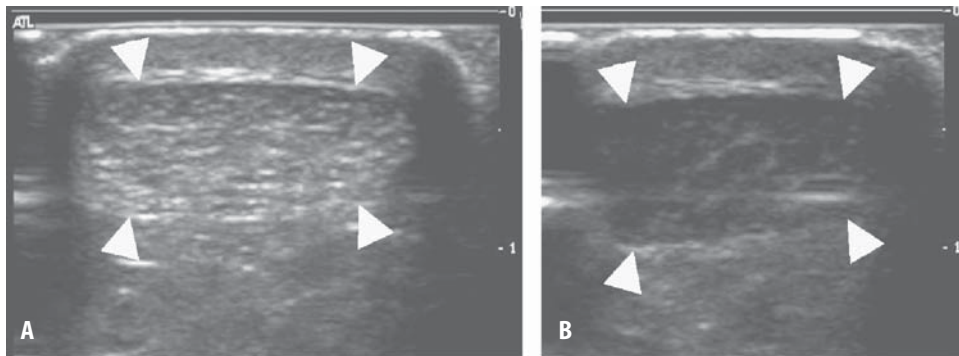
Transverse ultrasound images of a normal Achilles tendon. (A) Probe orientated at 90° to the tendon demonstrating a normal oval echobright tendon (arrowheads). (B) Probe angled
